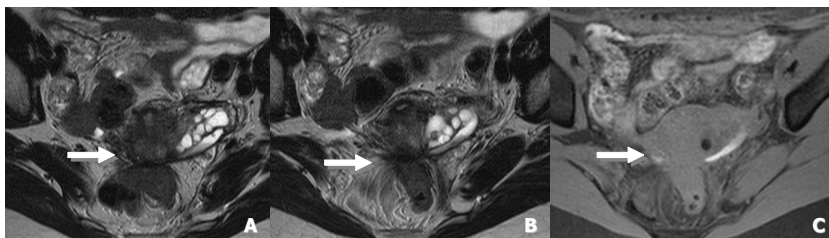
Diagnostic criteria of bowel invasion at MRI are: colorectal wall thickening with traction of the rectum toward the torus uteri (A, B, C).
